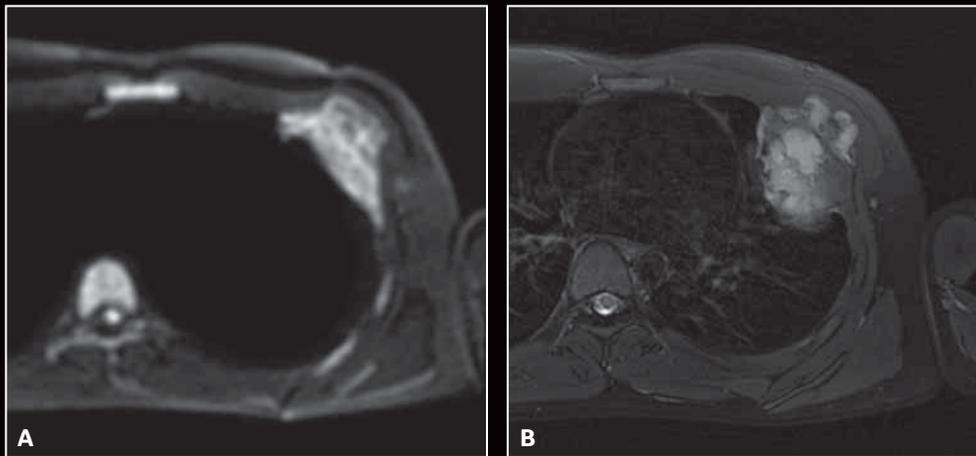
(A) MUSE was utilized for a DWI study of a patient with a suspected bone tumor in the fourth rib. (B) Axial T2w PROPELLER, FOV 24 cm, Th/Sp 5 mm/1 mm 256 x 256 in a scan time of 3:22 min.
